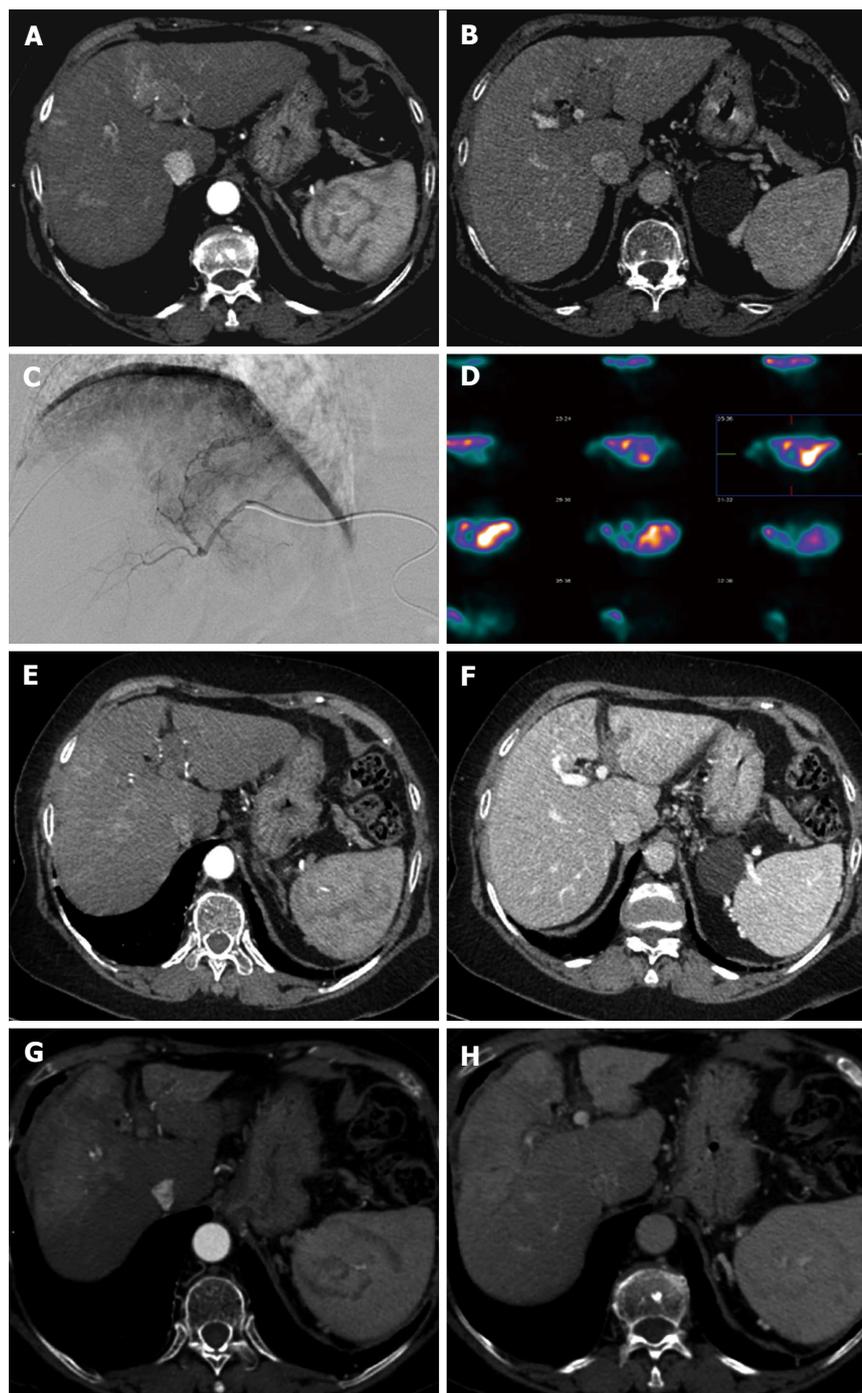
Treatment with Yttrium-90 and response of infiltrative hepatocellular carcinoma. A and B: The pretreatment computed tomography (CT) showing infiltrative hepatocellular carcinoma in the IV segment with associated tumor thrombosis of the left portal branch as visualized in the arterial phase and in the portal-venous phase; C: The pretreatment angiogram carried out with selective catheterization of the left hepatic artery, arising from the left gastric artery, confirms the hypervascularization of the venous thrombus; D: The pretreatment ^{99m}Tc -MAA single photon emission computed tomography images showing the corresponding uptake of MAA in the region of interest (tumor thrombus); E and F: The CT performed 1 mo after treatment showing both a significant decrease of the enhancement of the portal venous thrombus and a reduction in the enlargement of the portal branch as a sign of response, better visualized at 1 year (G and H). Note the significant “shrinkage” of the left lobe and the compensatory hypertrophy of the contralateral hepatic lobe. ^{99m}Tc -MAA: ^{99m}Tc labeled macroaggregated albumin.
